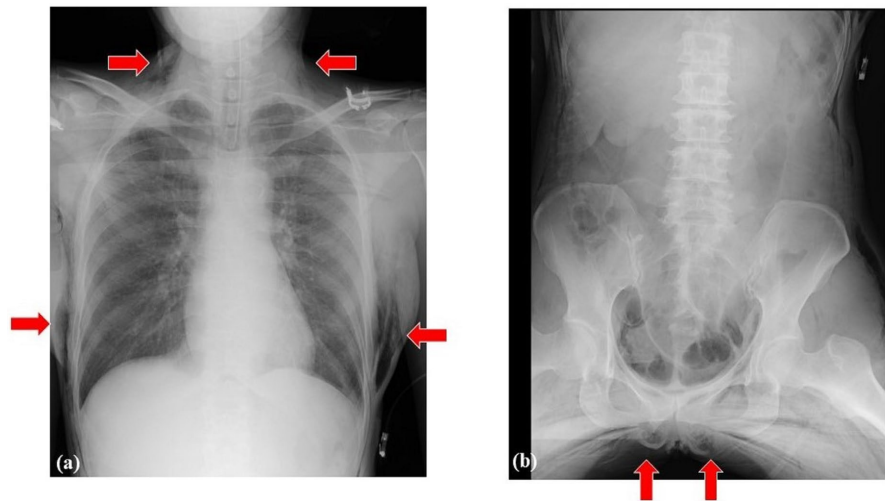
Chest and abdominal X-rays showing subcutaneous emphysema extending beyond the abdomen to the neck, thighs, and buttocks (arrows).
